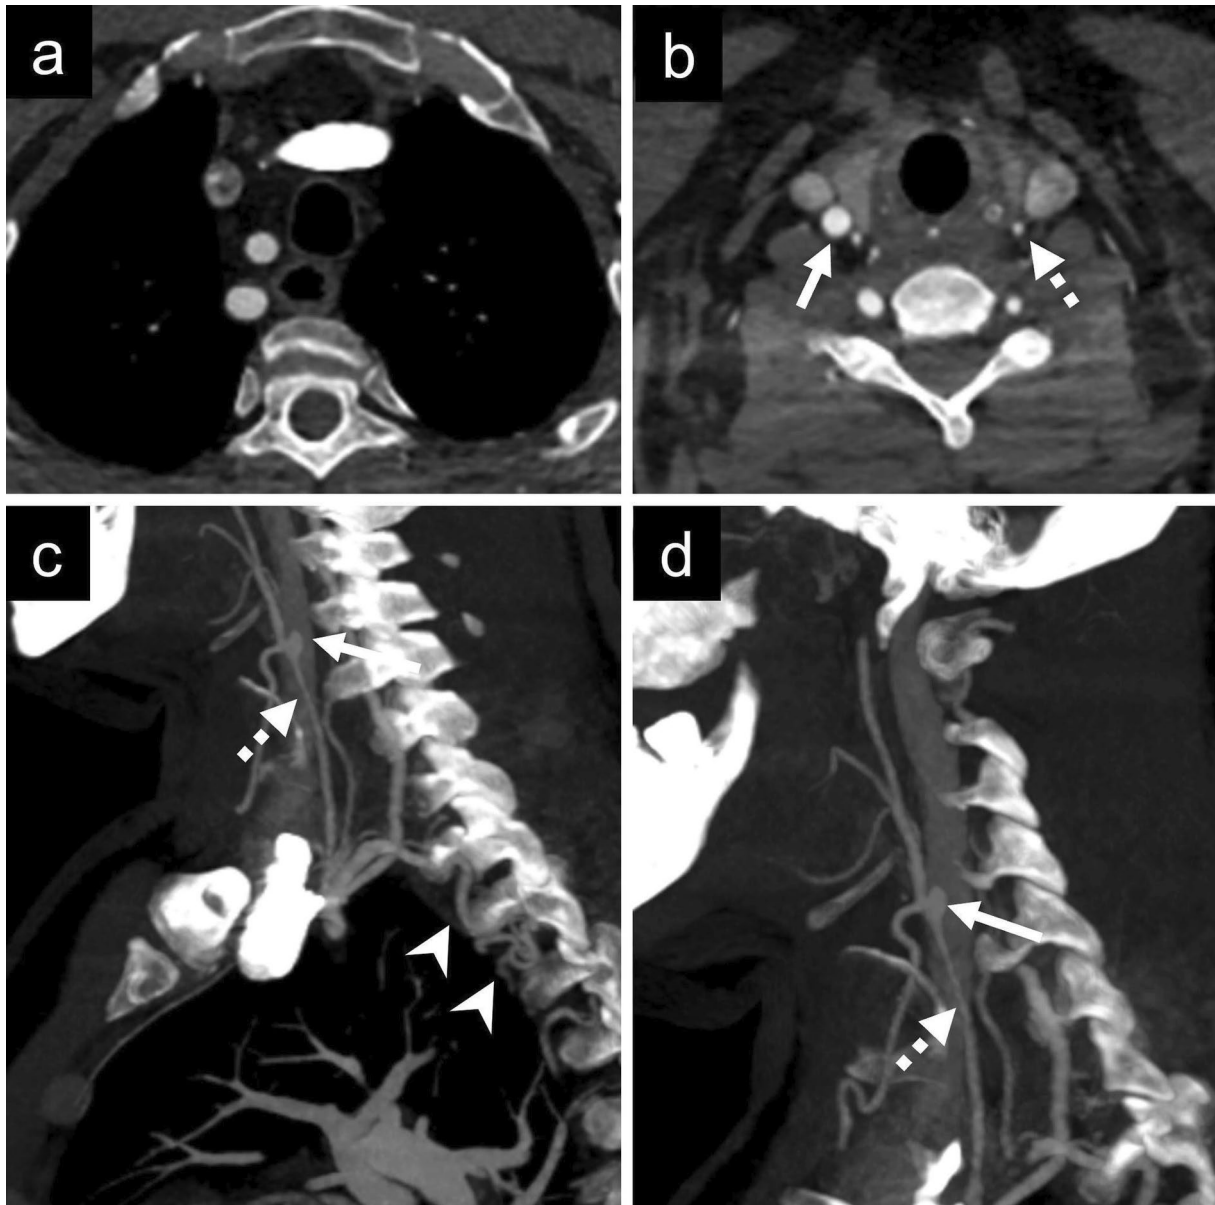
Axial CT image (a) above the aortic arch level shows the right common carotid artery and the right subclavian artery, the two vessels arising from the right aortic arch. In axial CT image at the level of the thyroid gland (b), the hypoplastic left common carotid artery (dashed arrow), and the normal right common carotid artery (solid
